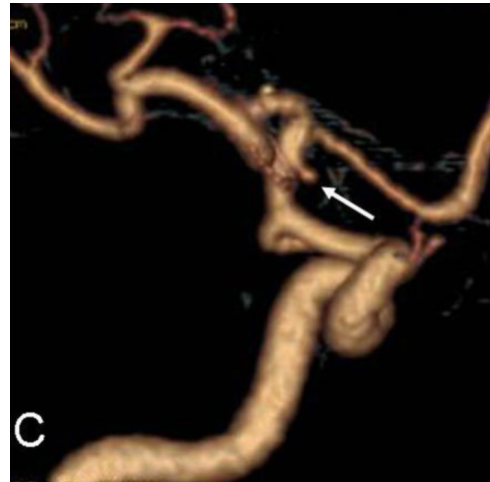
63-year-old female with anterior-wall aneurysm of the ICA. Followup 3D-CTA three months after the treatment shows remarkable decrease in the size of the aneurysm (arrow).
